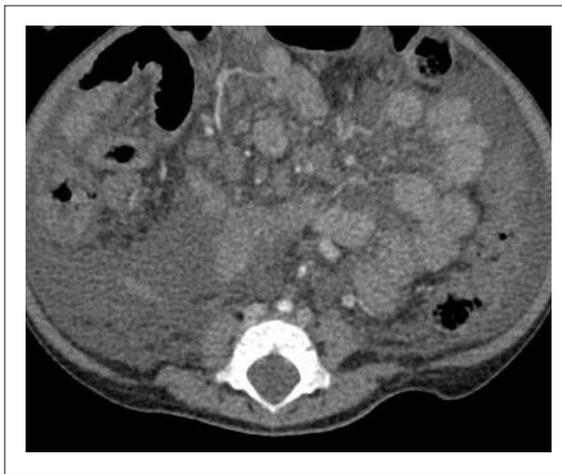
CT scan at mid abdomen showed moderate ascites. There are mild thickening small bowel loops.
